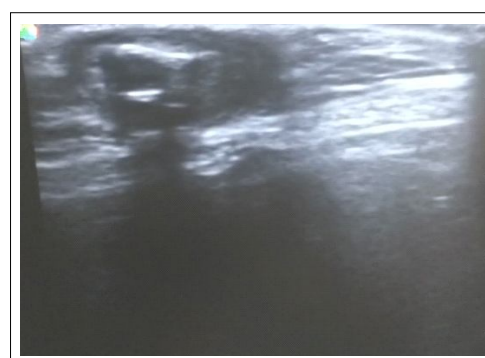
Group II post-operative (day 0) ultrasound of urethra- cross section.
